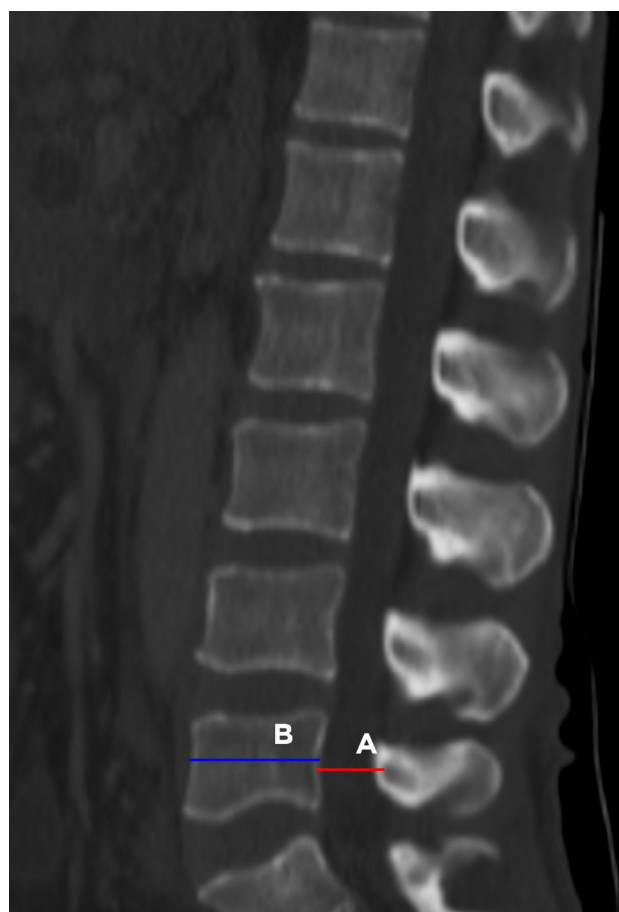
Midsagittal CT slice of vertebral column. The midsagittal diameter (A) and the antero-posterior diameter (B) of the vertebral body.
